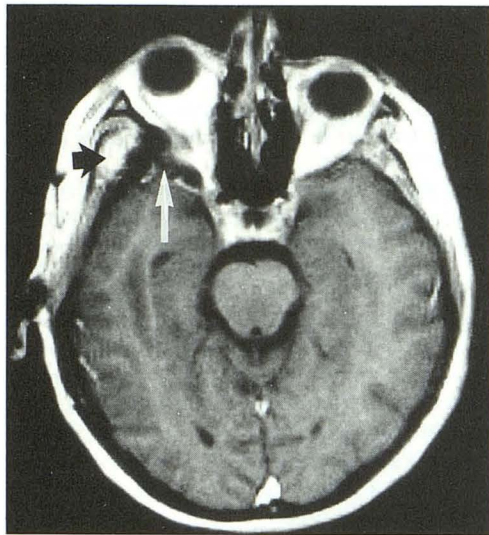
A–C, Demonstration of gadolinium enhancement in hyperostotic mass. Patient 1, right en plaque meningioma, second study, 6 years after first operation. Right exophthalmos. Extensive areas of bone resections in orbital walls and pterional vault. Marked new bone formation in lateral walls of right sphenoidal sinus and ethmoidal cells. Axial CT and MR.
